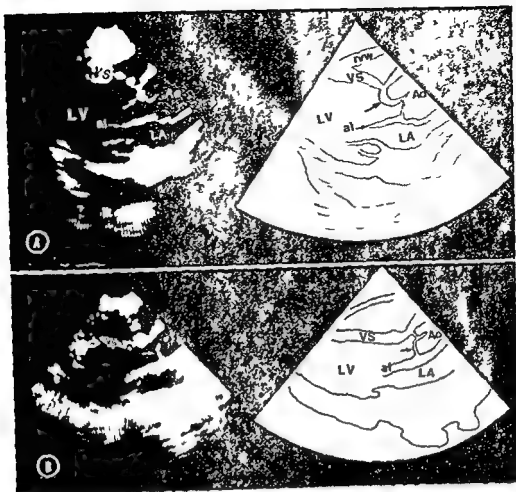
A A left ventricular longitudinal cross sectional echocardiogram from a patient with aortic valve prolapse demonstrating the left ventricle (LV) aorta (Ao) left atrium (LA) anterior mitral valve leaflet (al) and the right ventricular wall (rvw). The head of the white arrow lies well into the left ventricular outflow tract at mid mitral valve level and points to a marked prolapse and asymmetry of the right aortic valve cusp. B A left ventricular longitudinal cross sectional echocardiogram from a patient with aortic valve prolapse demonstrating the left ventricle (LV) left atrium (LA) aorta (Ao) and the anterior mitral valve leaflet (al). The white arrow points to a prolapsed thickened and asymmetric large posterior aortic valve cusp.
